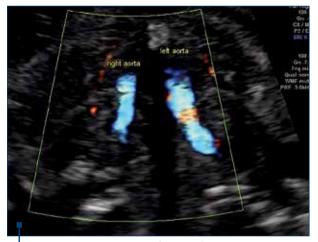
Color Doppler of the outflow tracts
